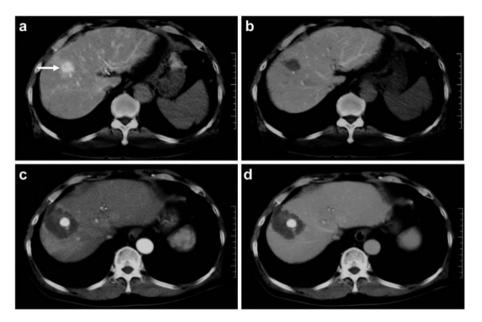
CT angiography (CT-A) and CT arterioportgraphy (CT-AP) were performed and dynamic computed tomography (CT) obtained one week after PMCT. Before treatment [CT-A (a), CT-AP (b)]. The tumor site (white arrow, tumor size = 1.7 cm in greatest dimension) is demonstrated as an enhanced area and perfusion defect is observed on CT-AP. This tumor was treated with one needle insertion. One week after treatment [early phase (c), portal phase (d)]. PMCT induced a sufficient treated margin. The tumor and the surrounding area were not enhanced. Accumulation of iodized oil was observed in the tumor. The coagulated area was 3.9 cm in maximal diameter and 3.3 cm in minimal diameter.
